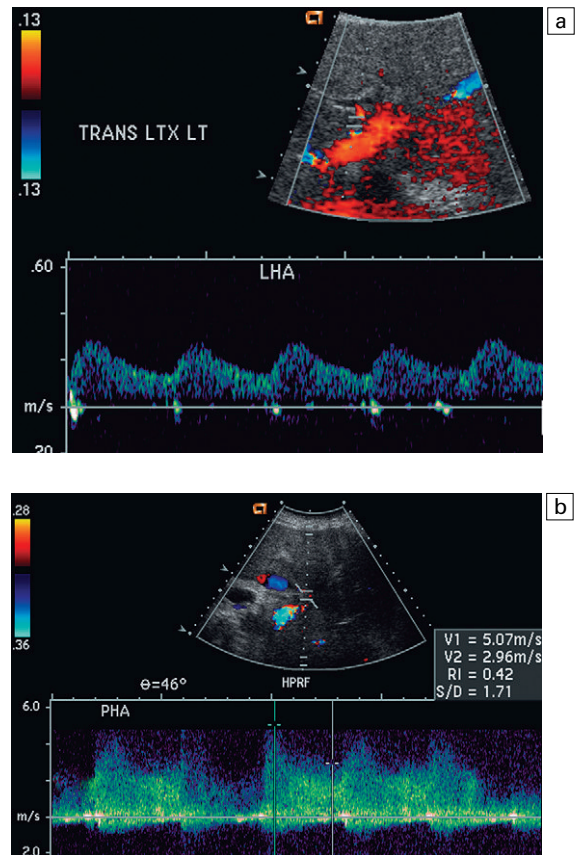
(a) Colour and spectral Doppler tracing of an intrahepatic arterial flow profile. Tardus parvus pattern with a delayed upstroke in systole rounded systolic curve and relatively low resistance flow is indicative of insufficient hepatic arterial inflow and suggests stenosis. The examiner should carefully walk the sample volume down the hepatic artery and out of the liver looking for the anticipated point of stenosis. In this case, (b) a high velocity jet measuring over 5 m s^{-1} identified the point of stenosis in the subhepatic space.
